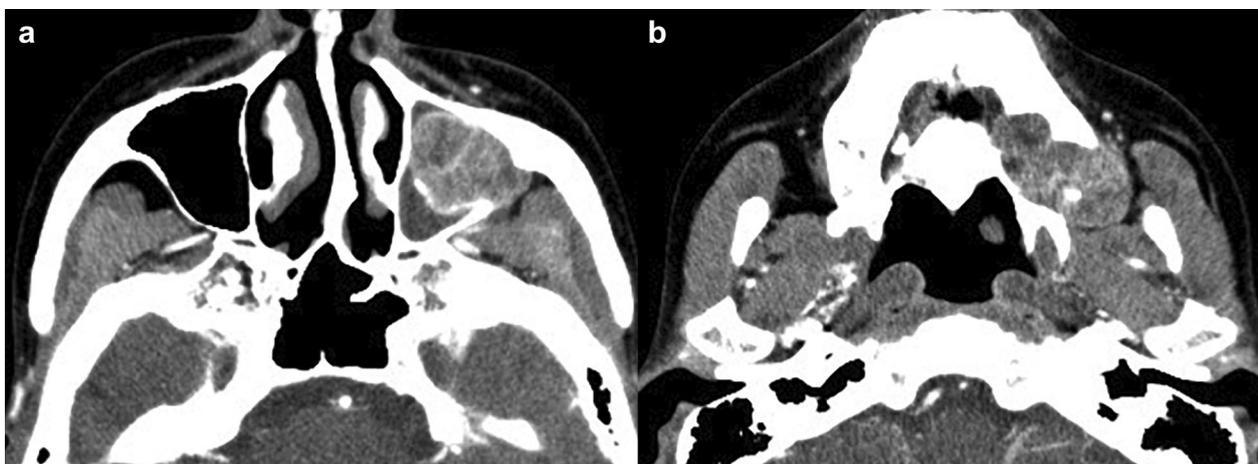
Images of case 4. Tumor in the left maxillary sinus partially destroys the posterior wall. a Horizontal section of computed tomography. b Coronal section of computed tomography
